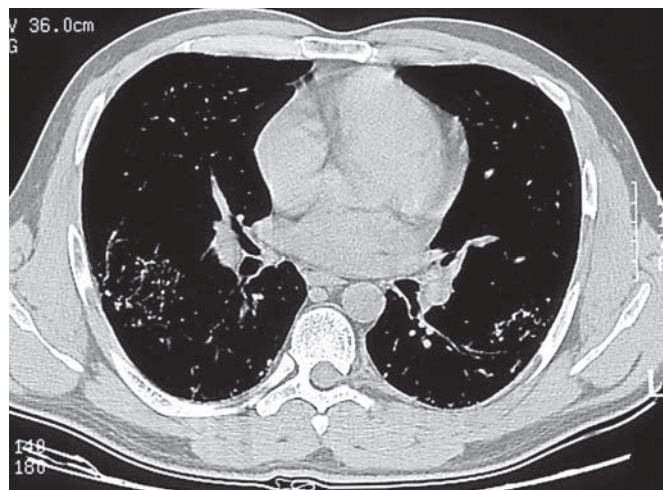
Idiopathic dendritic or racemose pulmonary ossification. HRCT scan at the lung basis. Irregular lines with bone density in both lower lobes.
